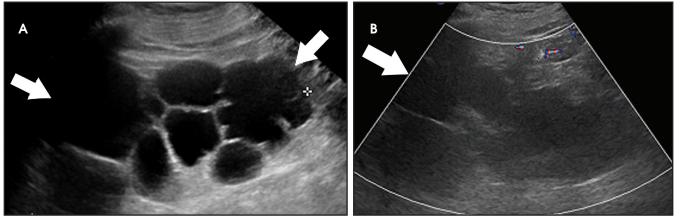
Multicystic dysplastic kidney (MCDK) in a 53-year-old man. Ultrasound (A) and color Doppler (B) images of the right kidney show multiple cysts replacing the entire renal parenchyma (arrows) without any identifiable intrarenal vessels or pelvicalyceal system consistent with the diagnosis of MCDK.
